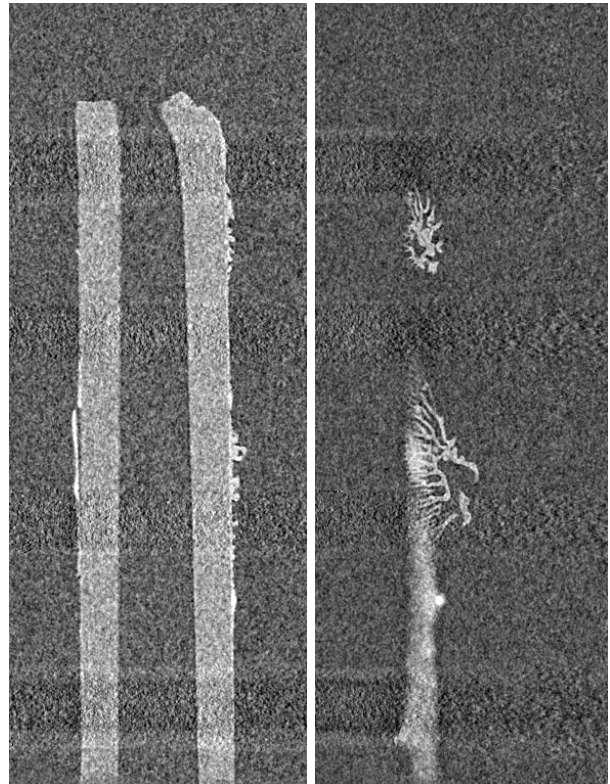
Coronal and sagittal sections of the reconstructed volume. Both sections show details within the glue on the outer surface of the hollow rod. On the left, the same detachment already shown in Fig. 4 is visible. The notable horizontal stripes are caused by the highly absorbing metal spheres, and their increased visibility at the top and bottom of the sample is a consequence of classic Feldkamp cone beam artifacts.
